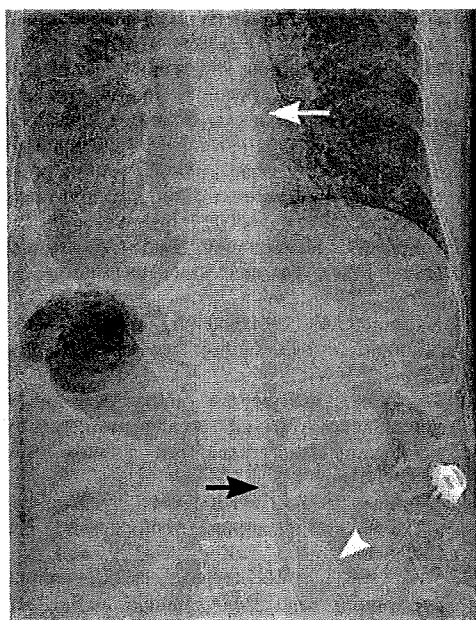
Abdominal radiograph of a 60-year-old woman. The catheter tip was placed in the right atrium (*white arrow*). *Black arrow*, IVC cannulation. *White arrowhead*, temporary entry site
